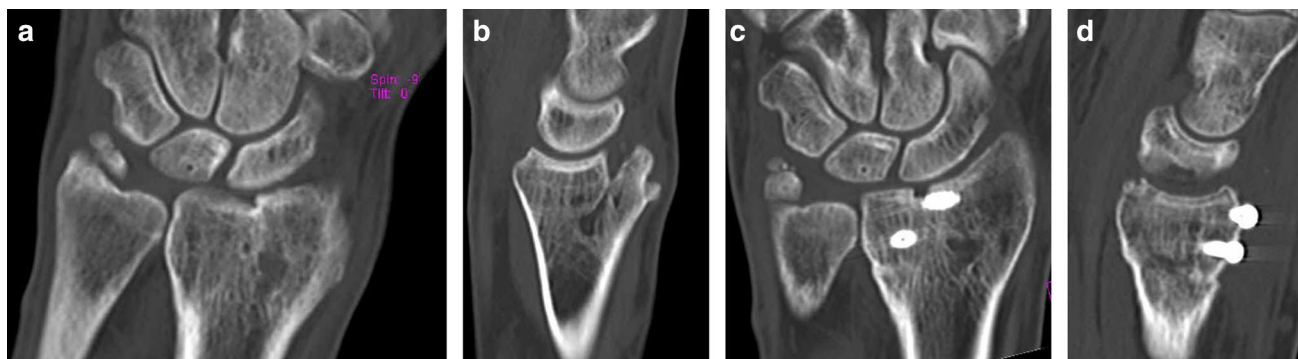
Correction of intra-articular offset formation following distal radius fracture. a Preoperative coronal CT scan of the wrist. b Preoperative sagittal CT scan of the wrist. c Postoperative coronal CT scan
